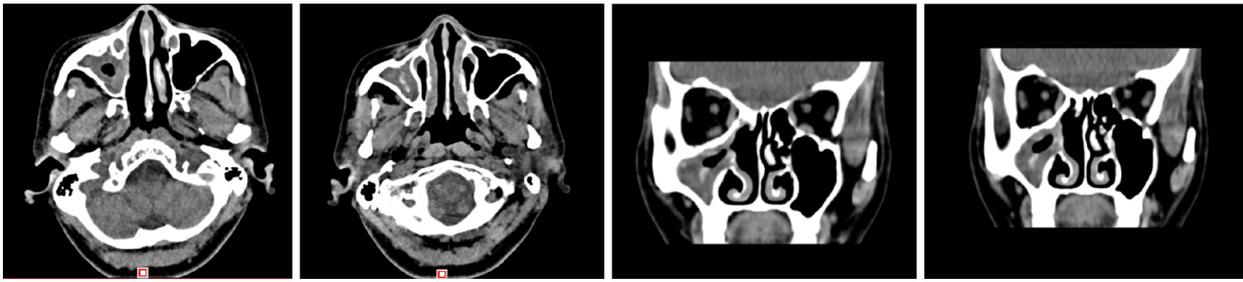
The second preoperative examination (October 19, 2017). Axial and sagittal paranasal sinus computed tomography scans showed that most of the ethmoid plates in the right ethmoid sinus were missing. Patchy, dense shadows were visible in the right maxillary sinus, and strips of dense shadows were visible in the right maxillary sinus. No abnormal bone tissue was observed in the sinus wall.
